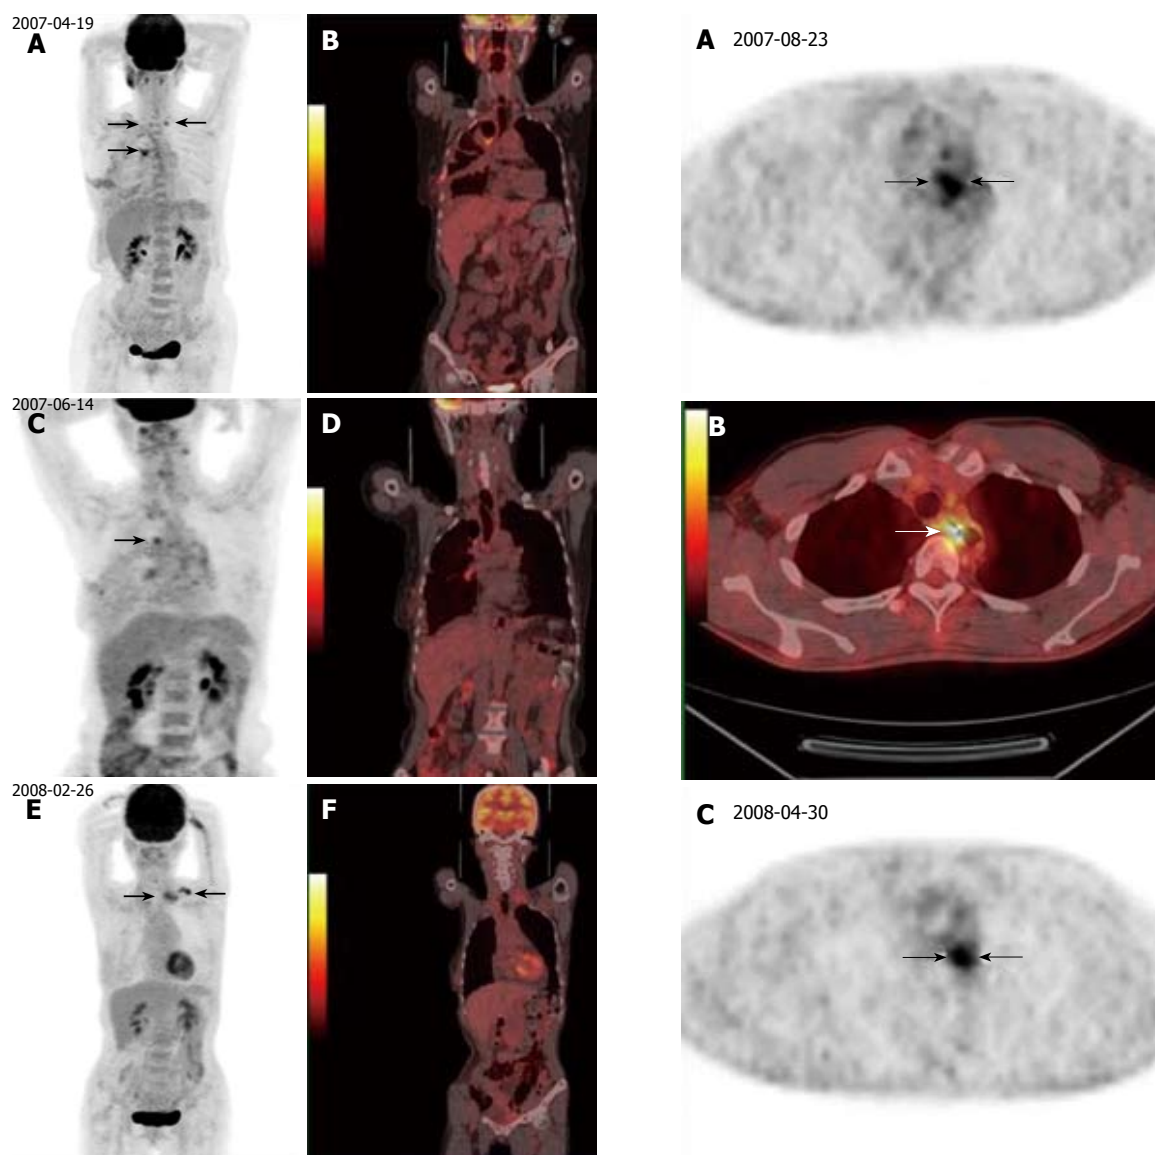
A 62-year-old woman had esophageal cancer resection. She underwent three PET/CT scans (1.5, 4.5 and 11 mo after treatment, respectively) as part of routine post-operative surveillance. The first PET/CT imaging (1.5 mo) revealed hypermetabolic activity in the anastomosis and supraclavicular lymph nodes (arrows, A, B). The second PET/CT imaging (4.5 mo) showed decreasing of hypermetabolic activity at anastomosis and supraclavicular lymph nodes (arrows, C, D). The third PET/CT imaging (11 mo) showed no abnormal FDG uptake at anastomosis, but revealed new focal hypermetabolic activity at left supraclavicular lymph nodes (arrows, E, F). Inflammation of lymph nodes and anastomosis at the first and second PET/CT scan were confirmed by the third PET/CT examination. New relapse at the left supraclavicular lymph nodes was later verified by biopsy.
